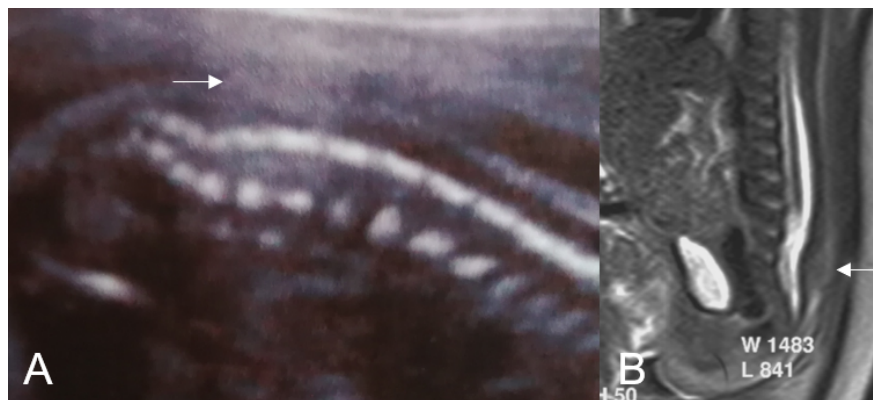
Caudal regression syndrome. A: Prenatal ultrasound image showing a blunt termination of the spinal cord at a vertebra level that is higher than the normal (white arrow). B, C: Sagittal (B) and coronal (C) MR images showing a “blunt-ending” and “club-shaped” conus medullaris abruptly terminating at a higher vertebra level. D: Postnatal MR image showing dysplastic sacrum and the caudal nerve roots arranged in anterior and posterior bundles, known as, double-bundle arrangement of the caudal nerves.
